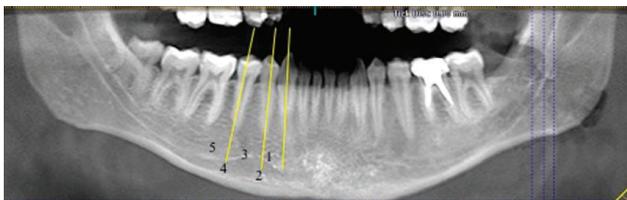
Panoramic reconstruction from a cone-beam computed tomography showing the method used to assess the horizontal position of the mental foramen.
